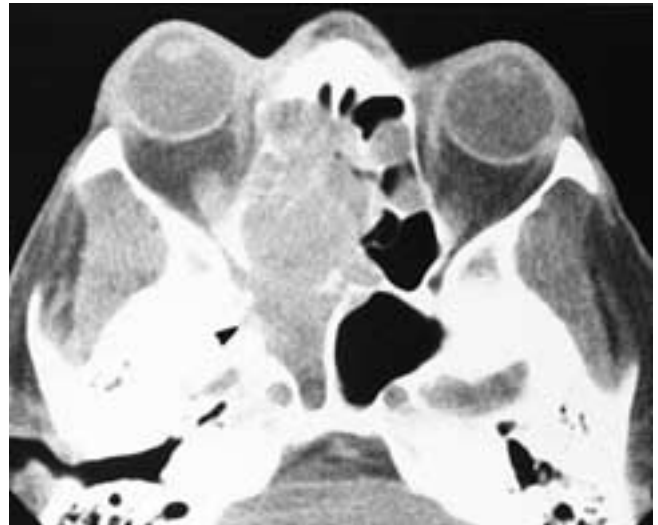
Axial CT scan shows a destructive lesion of the right ethmoid sinus that has extended into the nasal fossa and the sphenoid sinus. There is focal erosion of the skull base (arrowhead). This patient had a squamous cell carcinoma.
